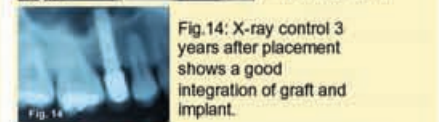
X-ray control 3 years after placement shows a good integration of graft and implant.
